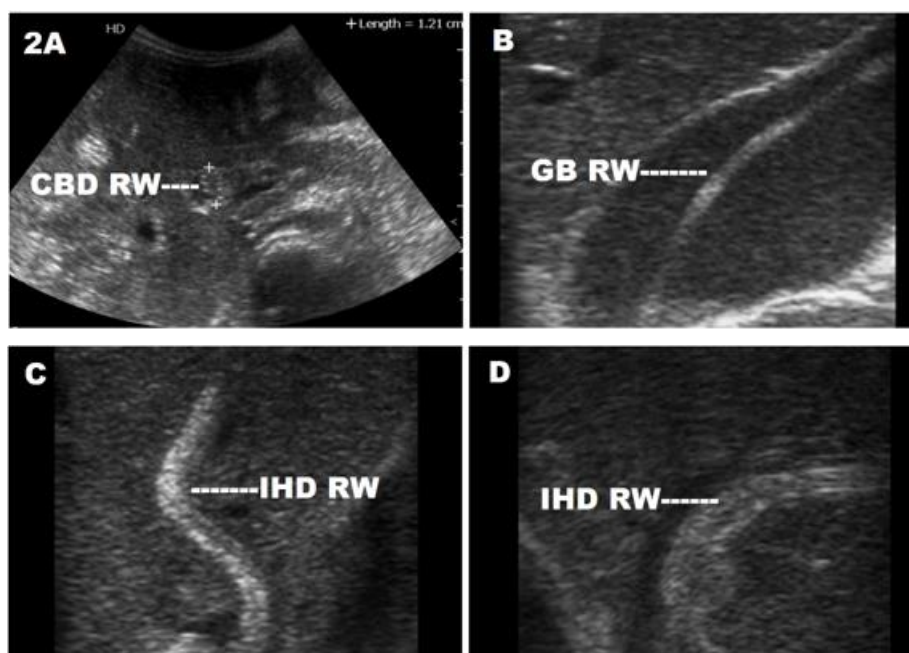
Sonography of Ascariasis. A. Sonography using curvilinear probe showing common bile duct (CBD) round worms (RW) in cross section. B. Sonography using linear probe showing round worm (RW) in the gall bladder (GB) seen as a non-shadowing strip without the inner tube 'Strip sign'. C&D. Sonography using linear probe showing round worms (RW) in the intrahepatic ducts (IHD).
